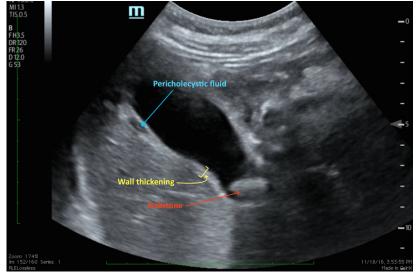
Ultrasonography. Acute calculous cholecystitis.
